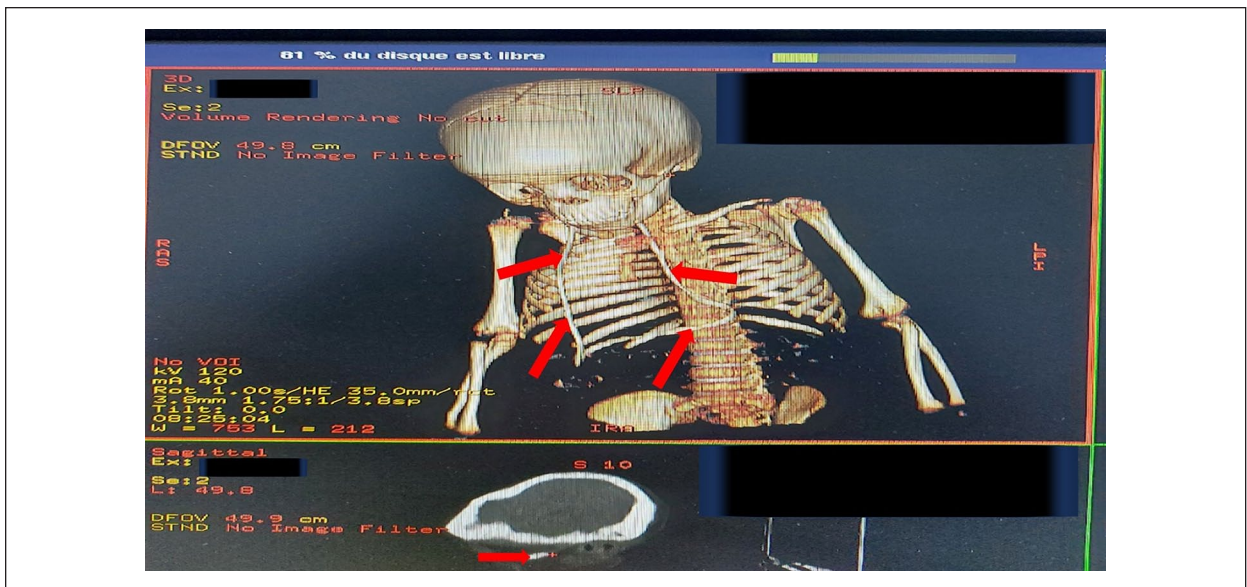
3-D Head-thoraco-abdominal CT-Scan showing the ventriculoperitoneal shunt system (Red arrows).
